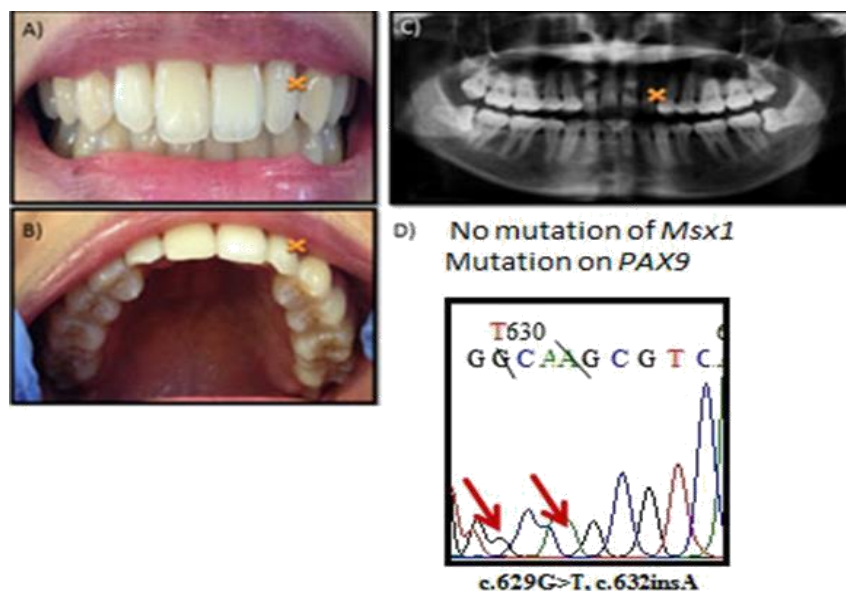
shows sample 1C (first daughter) of the family clinical findings (A, B) showing missing 23; radiographic findings (C) of the respective missing tooth are indicated using 'X'; and genetic findings (D) showing no mutation in MSX1, but point mutations were found on PAX9 exon 2 c.629G>T, c.632insA
